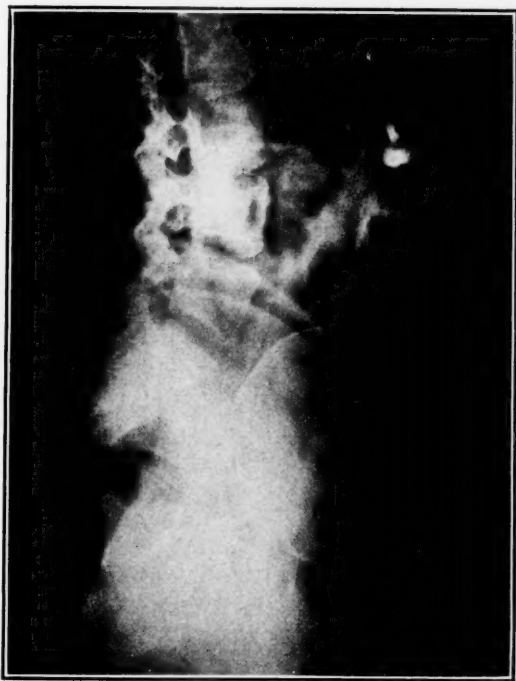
This roentgenogram shows faulty inclination of inlet. Engagement failed to occur and cesarean section was performed.
